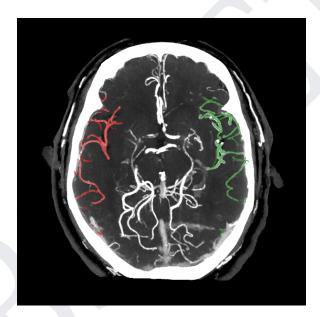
Example of StrokeViewer Collaterals output MIP image included in the summary report. Collateral flow of the affected hemisphere is presented in red, and collateral flow of the unaffected hemisphere is presented in green as an overlay in the CTA scan (one slice presented in this example).
